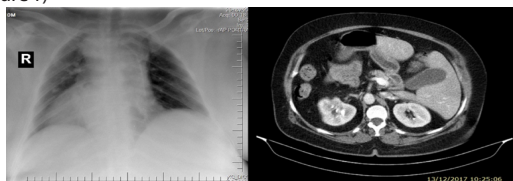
Chest X-ray (left) and computed tomography (right) of patient with situs inversus
